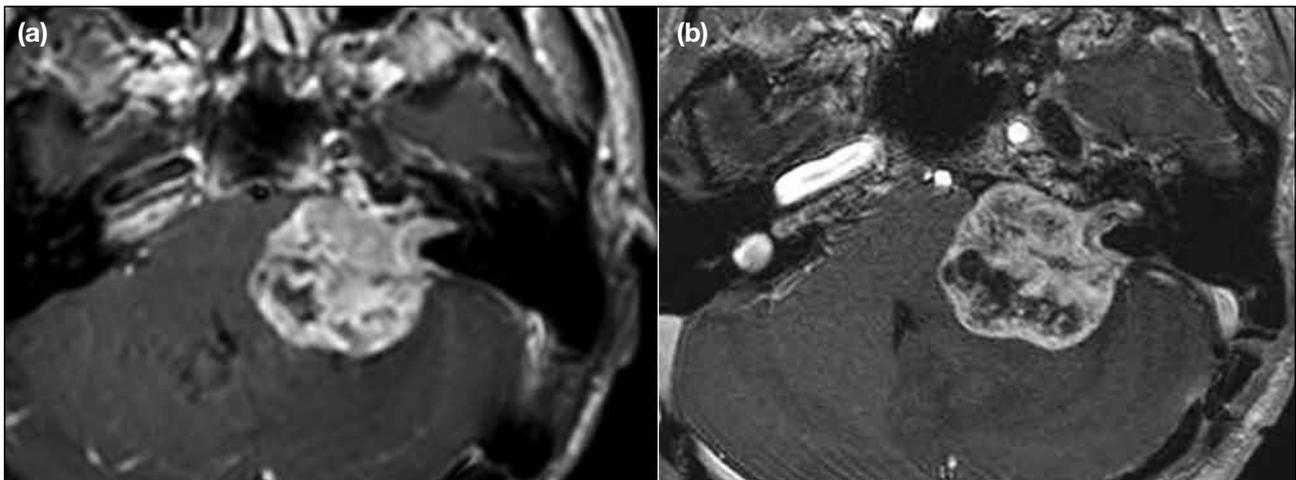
(a) Pre- and (b) post-fractionated stereotactic radiotherapy magnetic resonance images in a 57-year-old man with vestibular schwannoma.
